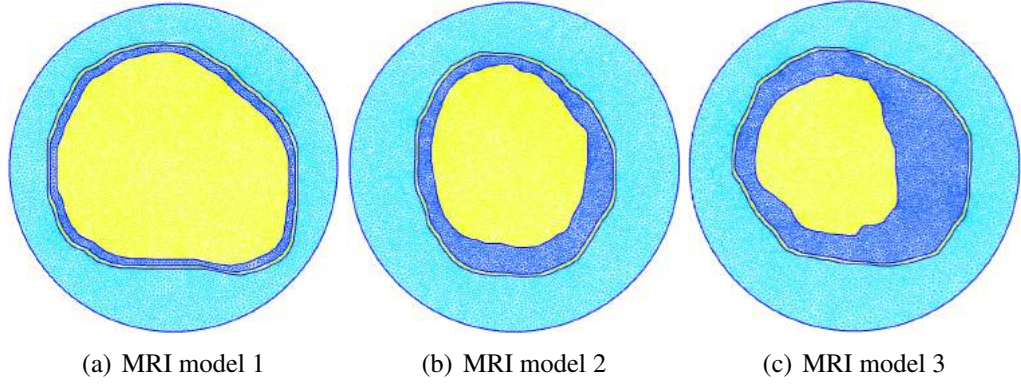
Inversion meshes with prior information about location and dielectric properties of tissues for MRI models 1, 2, and 3.
